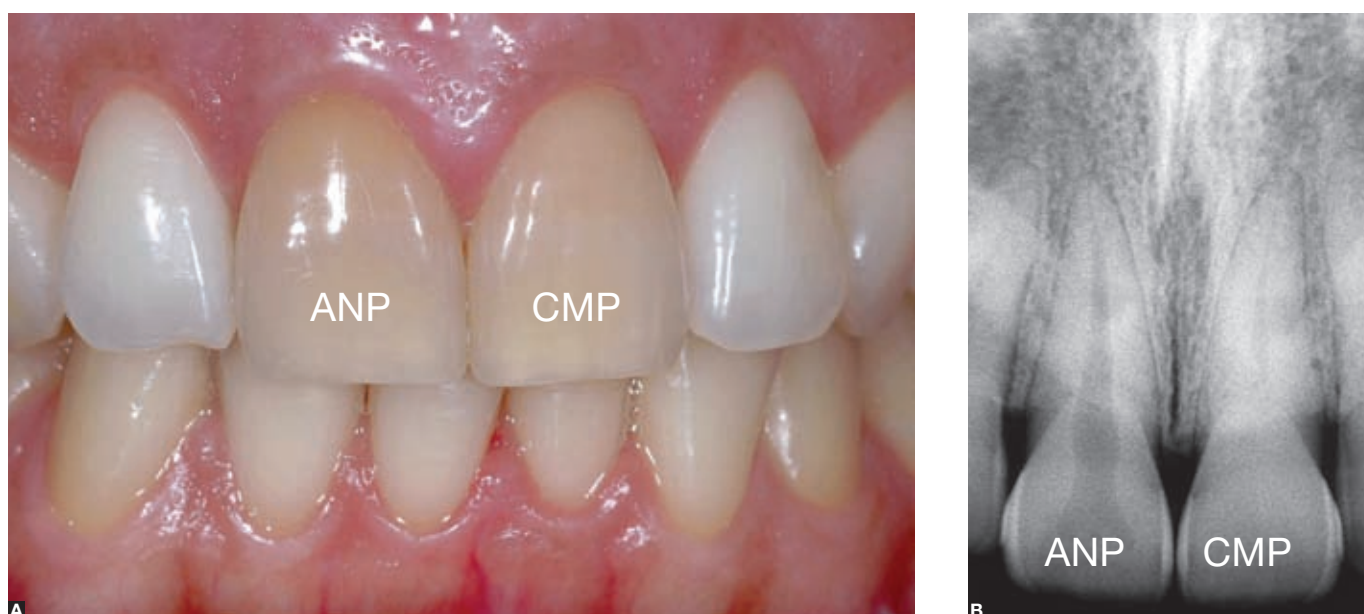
Discolorations of maxillary central incisors: Left incisor, due to calcific metamorphosis of the pulp (CMP) in intact tooth; and right incisor, due to aseptic necrosis of the pulp, both after dental trauma. Radiograph shows poorly-defined pulp canal margins, typical of calcific metamorphosis, when compared with aseptic necrosis of the pulp (ANP). Teeth had discoloration for years, but no symptoms; the two conditions were indistinguishable clinically.
